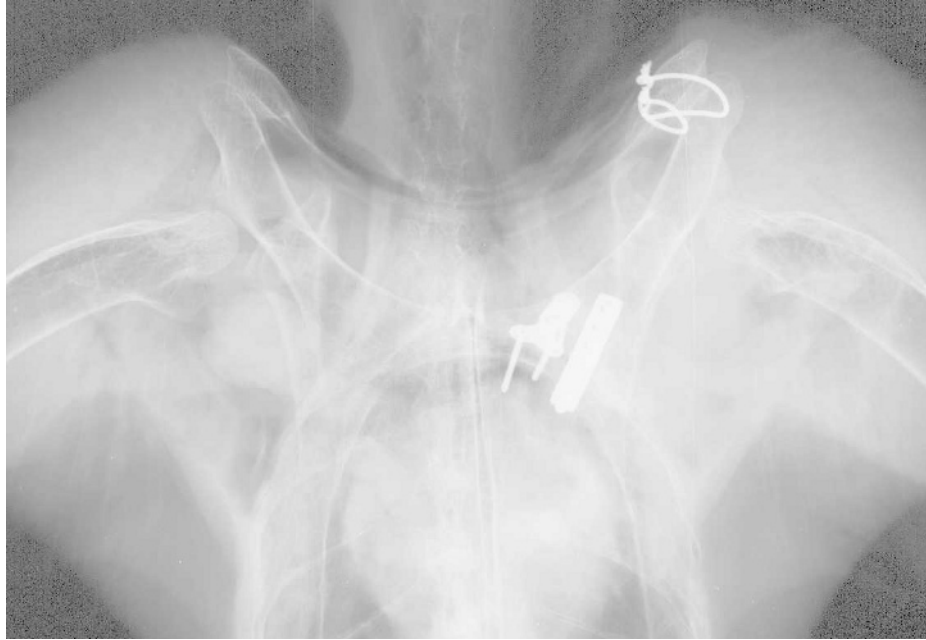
Ventrodorsal radiographic view of the eagle described in Figure 1, showing surgical repair of the left coracoid luxation with a T-plate, a compression plate, and cerclage wires.
